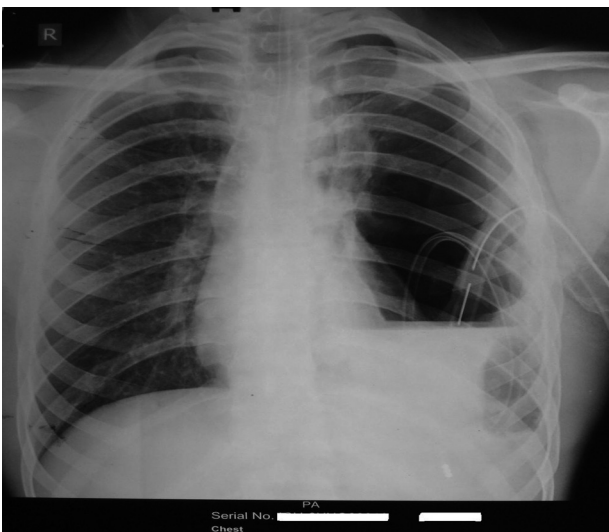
Chest radiograph (postero-anterior view) showing decrease air fluid level on the left side after inserting Ryle's tube.
